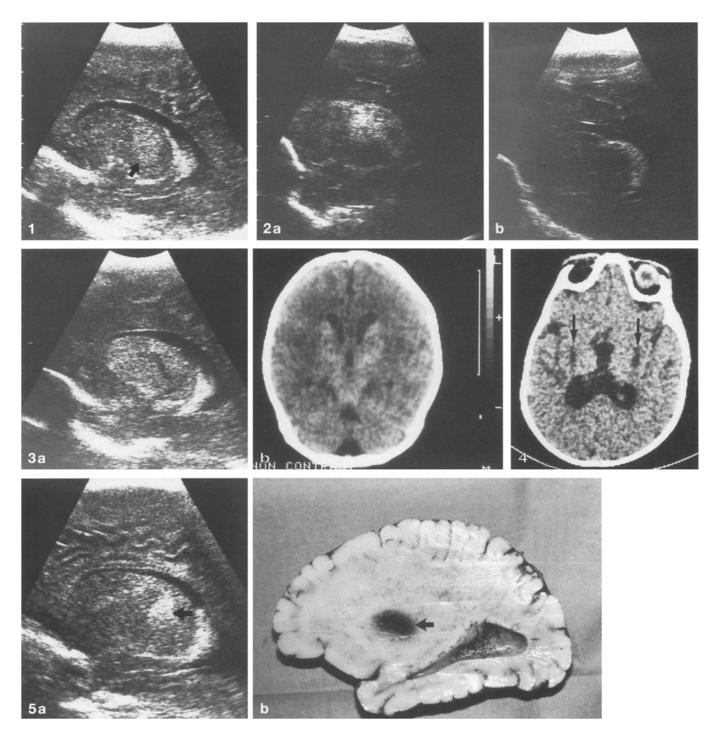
Sagittal sonographic image. There is increased echogenicity of the thalamic region (*arrow*)
